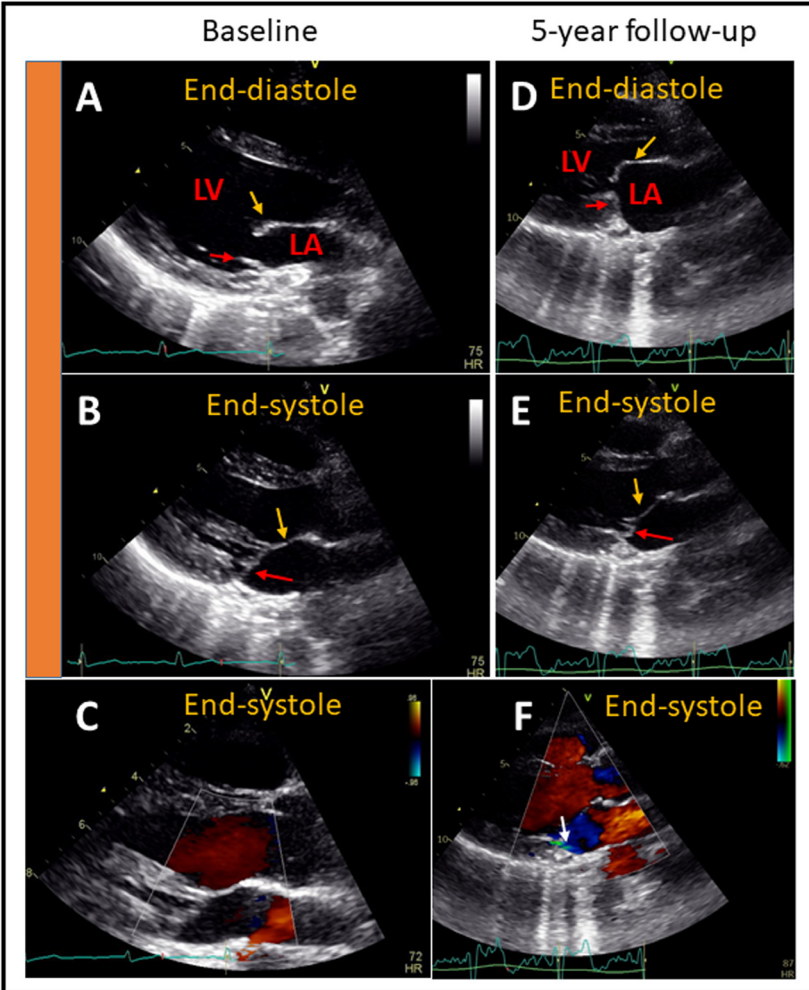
Echocardiographic images of a female patient in her 30s who was referred to general cardiology clinic for a standard transthoracic echocardiogram due to a low-grade, newly detected systolic murmur. At initial assessment (A-C), the anterior mitral valve leaflet was noted to be slightly elongated but had normal motion (A, yellow arrow), with no prolapse of mitral valve leaflets (B, yellow arrow shows anterior and red arrow posterior mitral valve leaflet) or mitral leak (C). At 5-year follow-up (D-F), the anterior valve leaflet was again slightly elongated but had normal motion and left atrium size was normal (D). Posterior mitral valve leaflet (red arrow) which showed a mild (1 mm) bulging towards left atrium (E). A trace/mild mitral regurgitation was noted (F, white arrow). At 5-year follow, the systolic murmur was mild (grade II) with a blowing character changeable with respiration, hearable in expiration and disappearing in inspiration, suggesting an inspiratory decrease and expiratory increase in blood flow into the left atrium and ventricle affecting the intensity of the murmur. There was a “curling” movement of the basal part of the heart/atrioventricular junction, without any signs of mitral annulus disjunction or true prolapse. Acoustic windows were poor in apical views and respiratory change in mitral regurgitation could not be evaluated. Color version of figure is available online.
